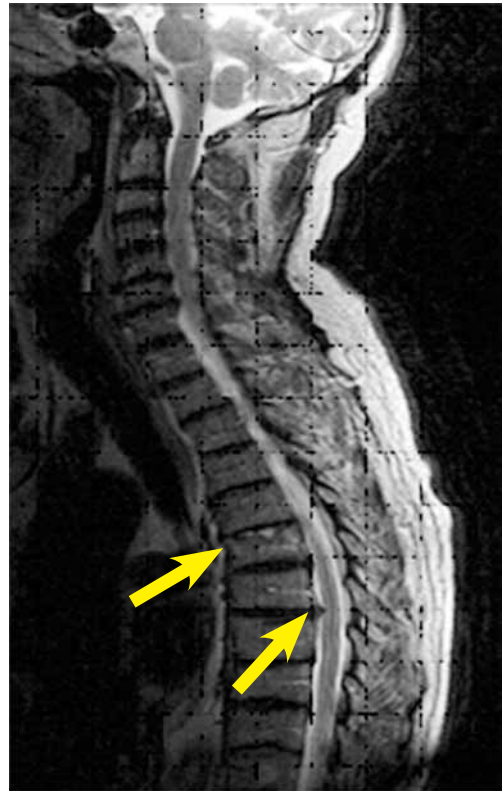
T2 MRI (sagittal image) of the spine cervical-thoracic level shows the fracture on the upper margin of the Th6. The intervertebral disc C3/C4 is presented with a dorsal median expansion. The intervertebral discs to the C5/C6 and C6/C7 are presented with a dorsal median expansion. The intervertebral discs to the Th2/Th3 and Th6/Th7 are presented with circular protrusions. Disc hernia to the Th7/Th8 with right dorsal paramedian expansion and narrowing of the spinal canal and signs of spinal compression.
